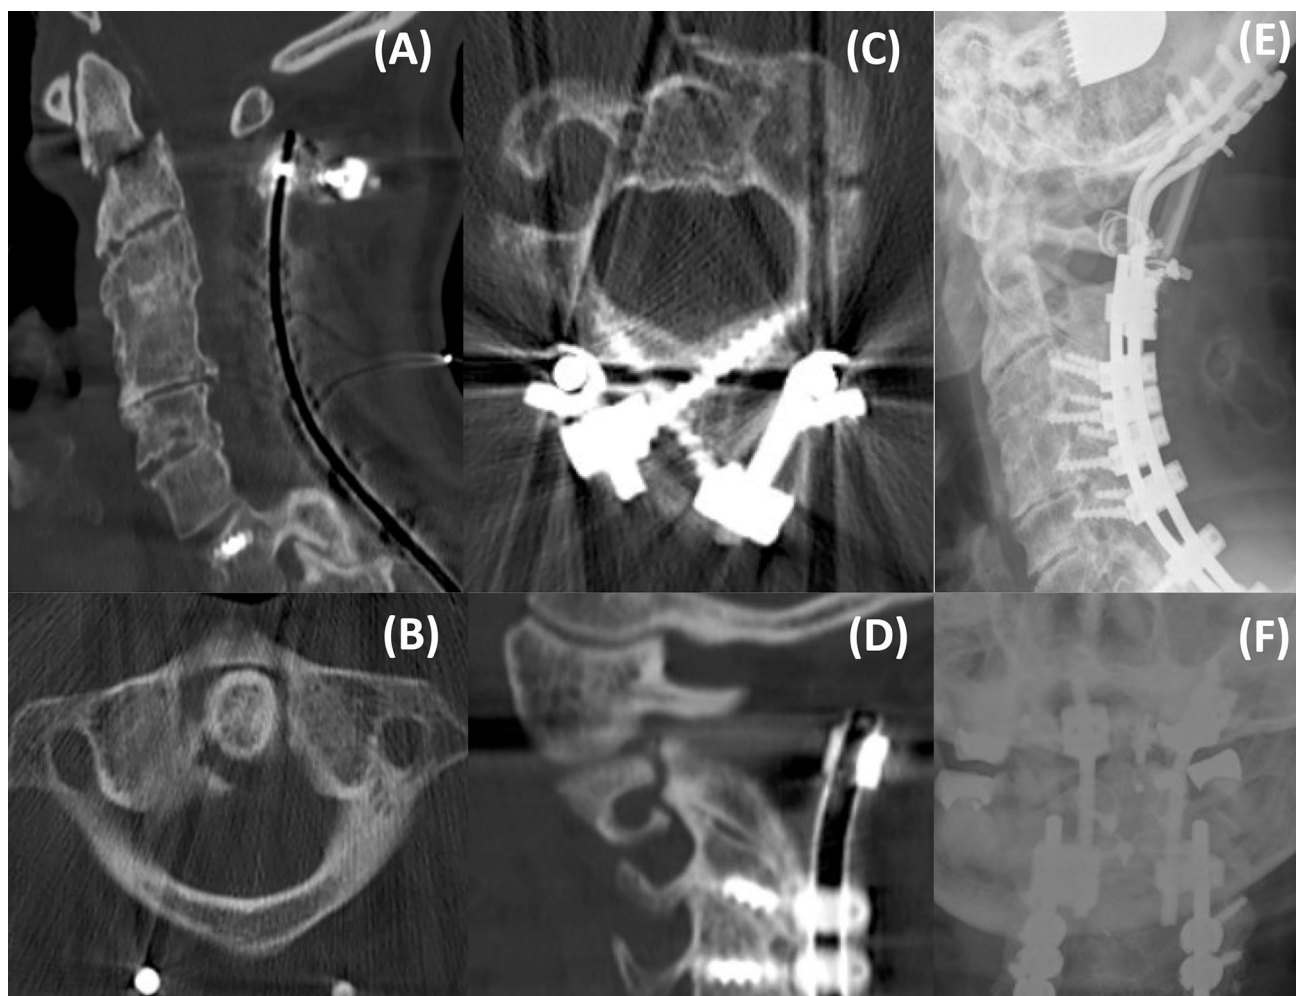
Three years after the previous C2-pelvis posterior spinal instrumented fusion, she hit her head against a wall after a fall. A CT scan of the cervical spine demonstrated an acute type II dens fracture
